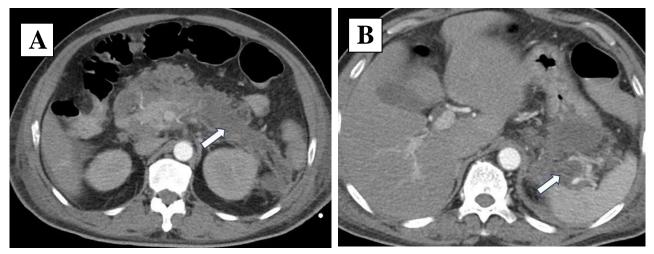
Contrast enhanced CT abdomen shows peripancreatic collections (white arrow in A) extending until splenic hilum (white arrow in B).
